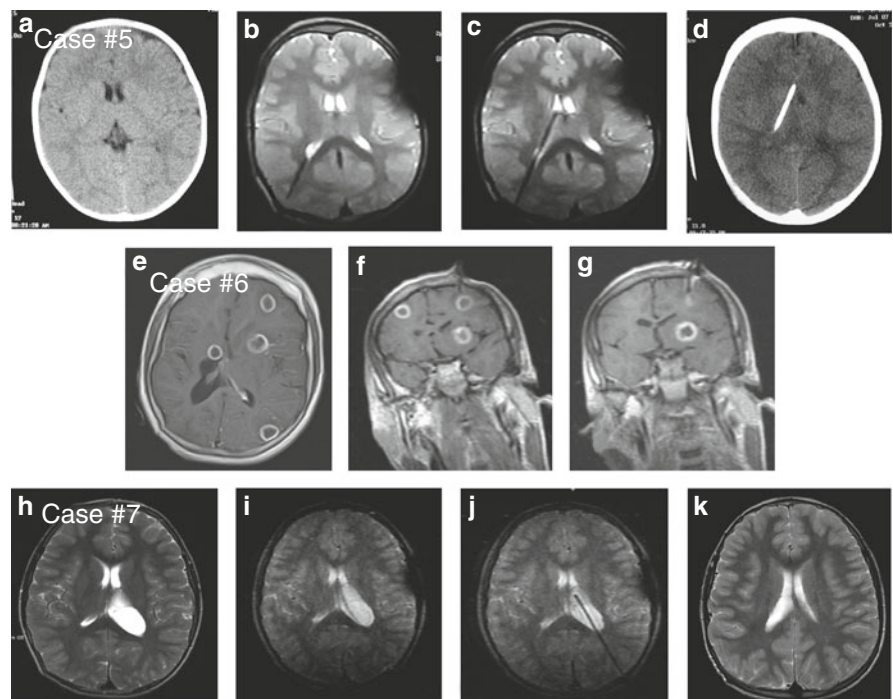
Case #5: Intracranial Hypertension with Slit Ventricles. Preoperative CT (a), intraoperative MRI showing stent placement on first pass (b, c), and post operative CT images (d). Case #6: Abscess Drainage. Preoperative image (e) showing patient with multiple small streptococcal abscesses. Intraoperative imaging immediately prior to and following abscess drainage (f, g). Case #7: Multiloculated Intraventricular Cyst. Preoperative (h) and intraoperative images showing a missed first pass (i) and a successful fenestration (j). Postoperative image showing decreased left lateral ventricle
